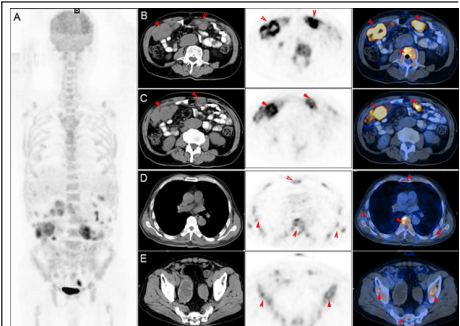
Images of 18F-FDG PET/CT scan were acquired 1 hour after intravenous injection of 10 mCi of 18F-FDG with a blood glucose level of 76mg/dL (A). The images showed multiple peritoneal mass with soft tissue density and had an elevated FDG uptake with SUVmax of 8.5 (B,C). In addition, the cervical, thoracic and lumbar vertebra presented with wide range of high metabolism signs with increased FDG uptake (SUVmax, 4.8) (B,D,E), but no bone destruction presentation.
